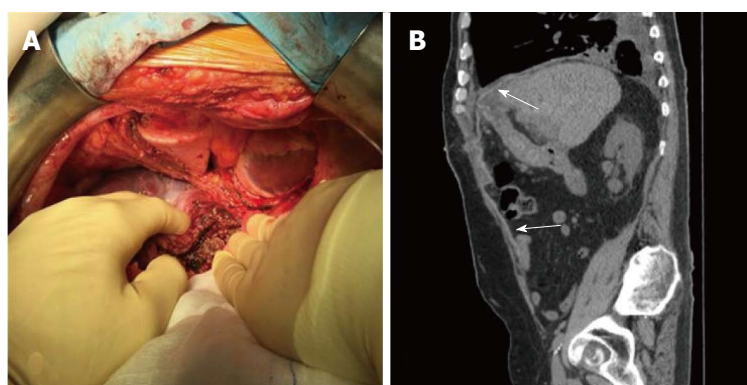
The abdominal exploration showed a neoplasm of left lobe liver graft with infiltration of the diaphragm which extended to the pleura and pericardium. A: Left liver lobectomy of the graft with resection of the diaphragm "en bloc" with adjacent portion of right pleura and pericardium; B: Computed tomography scan at 6 mo after abdominal wall repair (arrow: Biological prosthesis).
